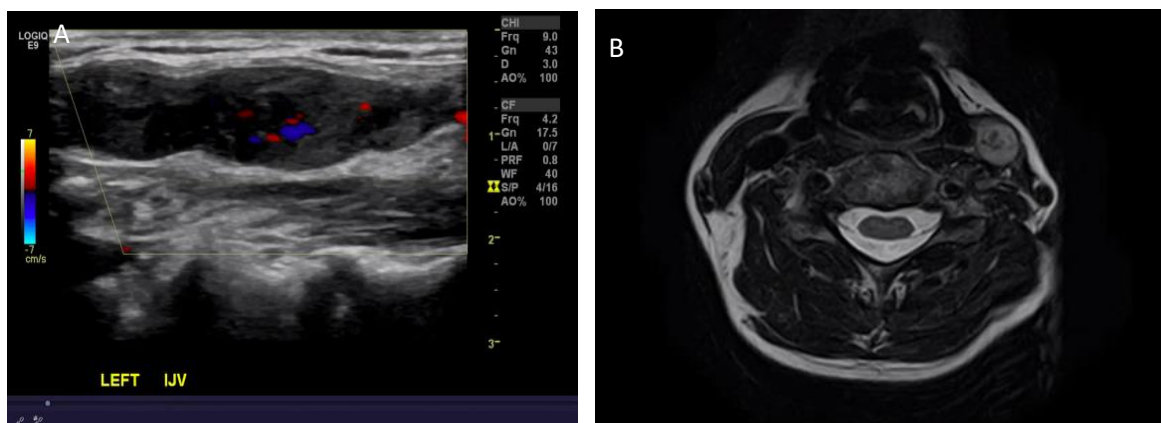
Color Doppler Ultrasound of the left Internal Jugular Vein (IJV) shows a hyperechoic thrombus within the IJV which fills the lumen and diminishes the normal color Doppler vascularity of the vein—Figure 1B: demonstrates an absence of normal flow void on the left IJV. The clot is isointense to hyperintense on T2 weighted image.
